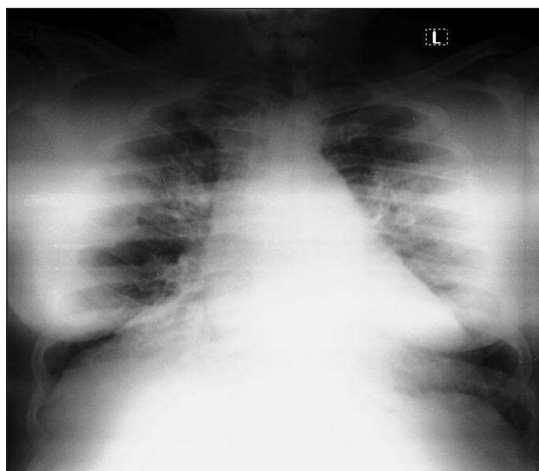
Chest radiograph of the patient (not pattern)
